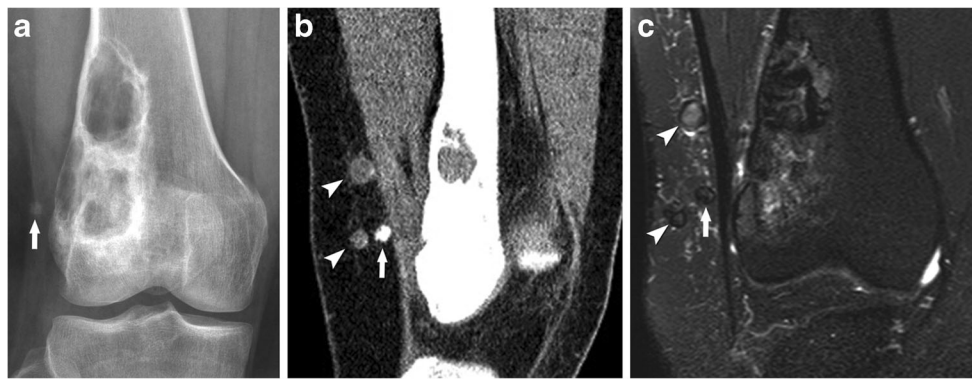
Case 3. A 26-year-old female with giant cell tumor in the distal femur. a Plain radiograph of anterior-posterior projection of the knee shows an increased density nodular lesion in the subcutaneous fat tissue layer, lateral to the bony lesion, near the incision site (*arrow*). Also seen is an irregular area of osteolysis in the superior and lateral aspect of the previously treated bony lesion of the distal femur, at the cement–bone interface, representing intraosseous tumor recurrence. b Reformatted
